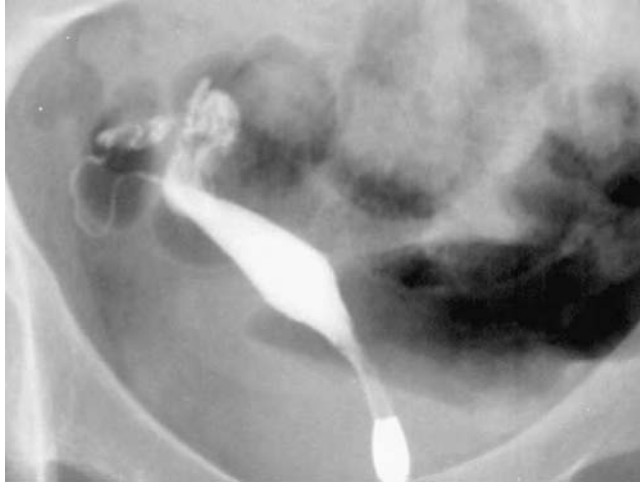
Unicornuate uterus. During this X-ray only the right horn of the uterine cavity filled. This is compatible with a unicornuate uterus. A unicornuate uterus increases the risk of premature labor and fetal malpresentations. It can be accompanied by renal abnormalities
